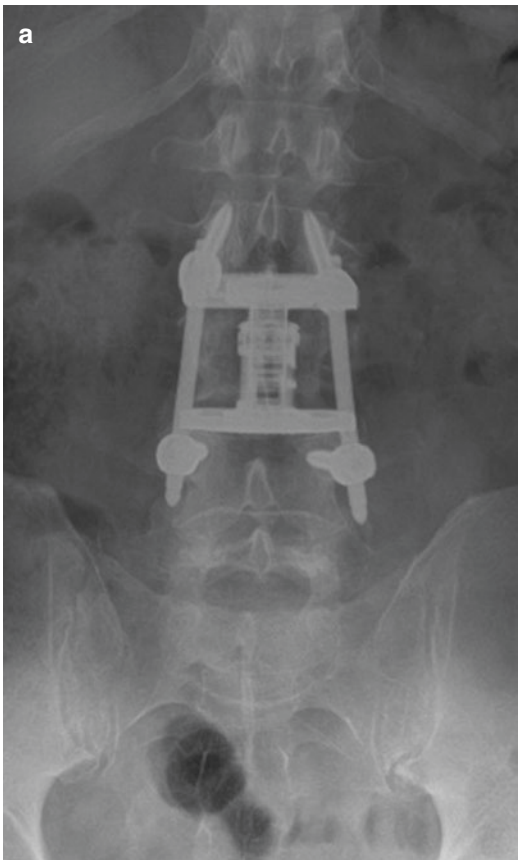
The anteroposterior (a) and lateral (b) postoperative radiographs of the patient from Fig. 18.7 following direct lateral corpectomy and reconstruction
